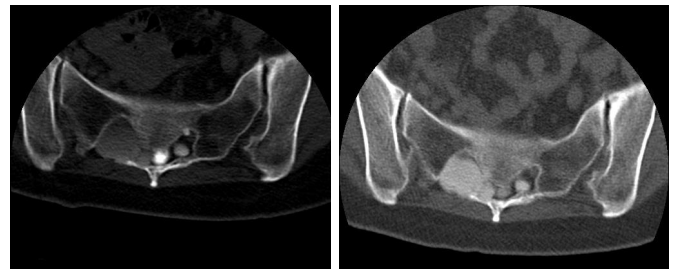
CT myelography: early post-contrast image. Fig. 2. CT myelography: late post-contrast image.
